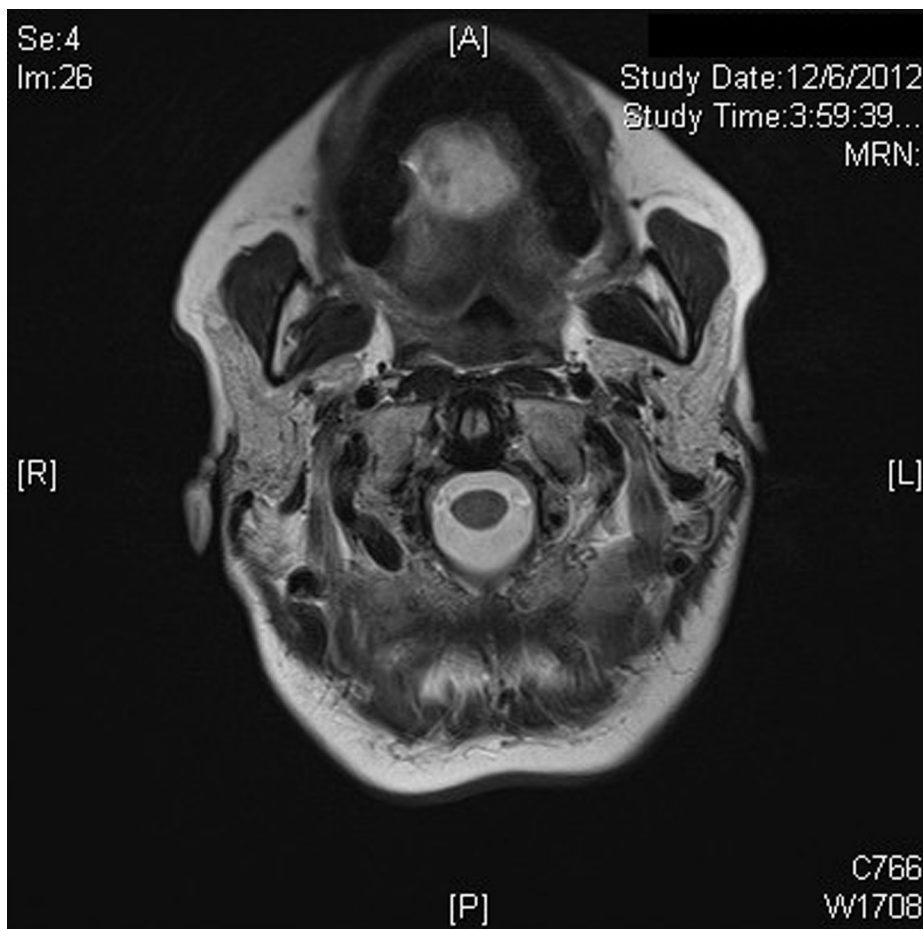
Preoperative T1-weighted magnetic resonance image—axial cut showing a 2-2-cm mass involving the right tongue and crossing the midline.
